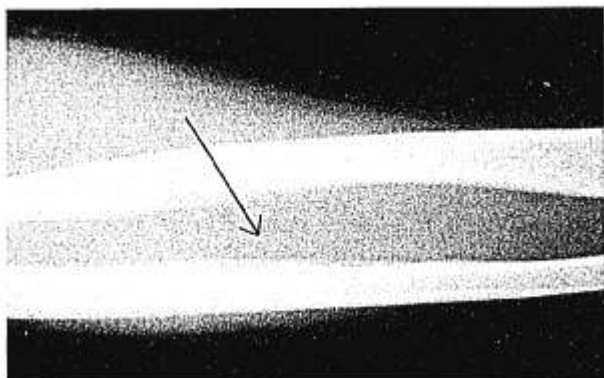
Radiograph of midshaft ulna stress fracture (arrow).
